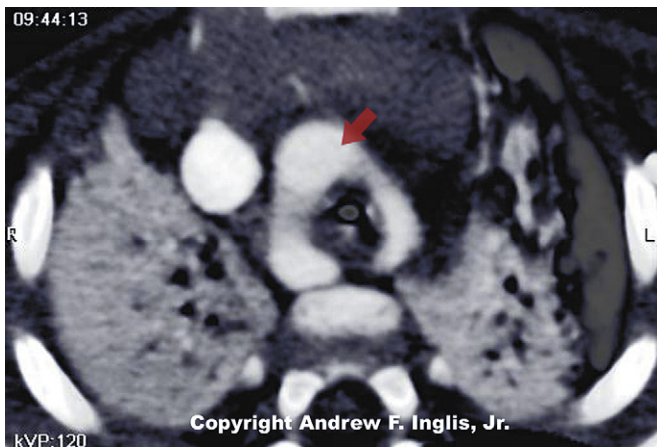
Contrast CT scan showing vascular ring encircling and compressing the trachea (arrow indicates vascular ring encircling trachea). (Copyright Andrew F. Inglis Jr.)
